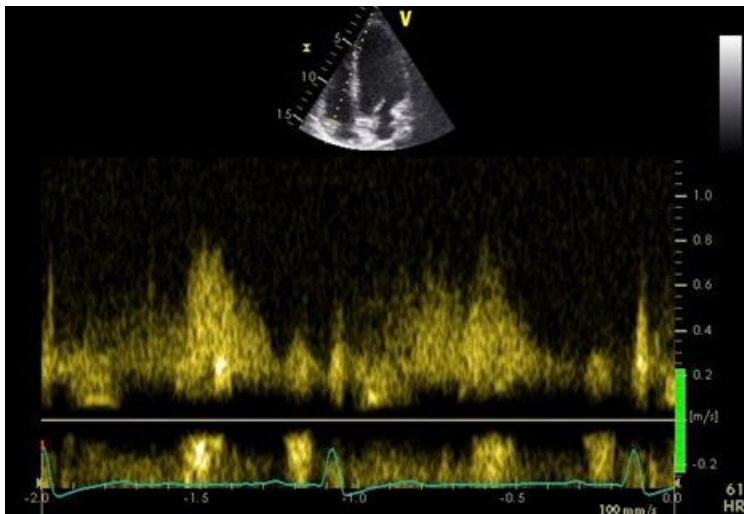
PW Doppler TV (A) and measurement PW Doppler TV (B), CW Doppler TV (C) to detect high velocities (exclusion of tricuspid stenosis)
